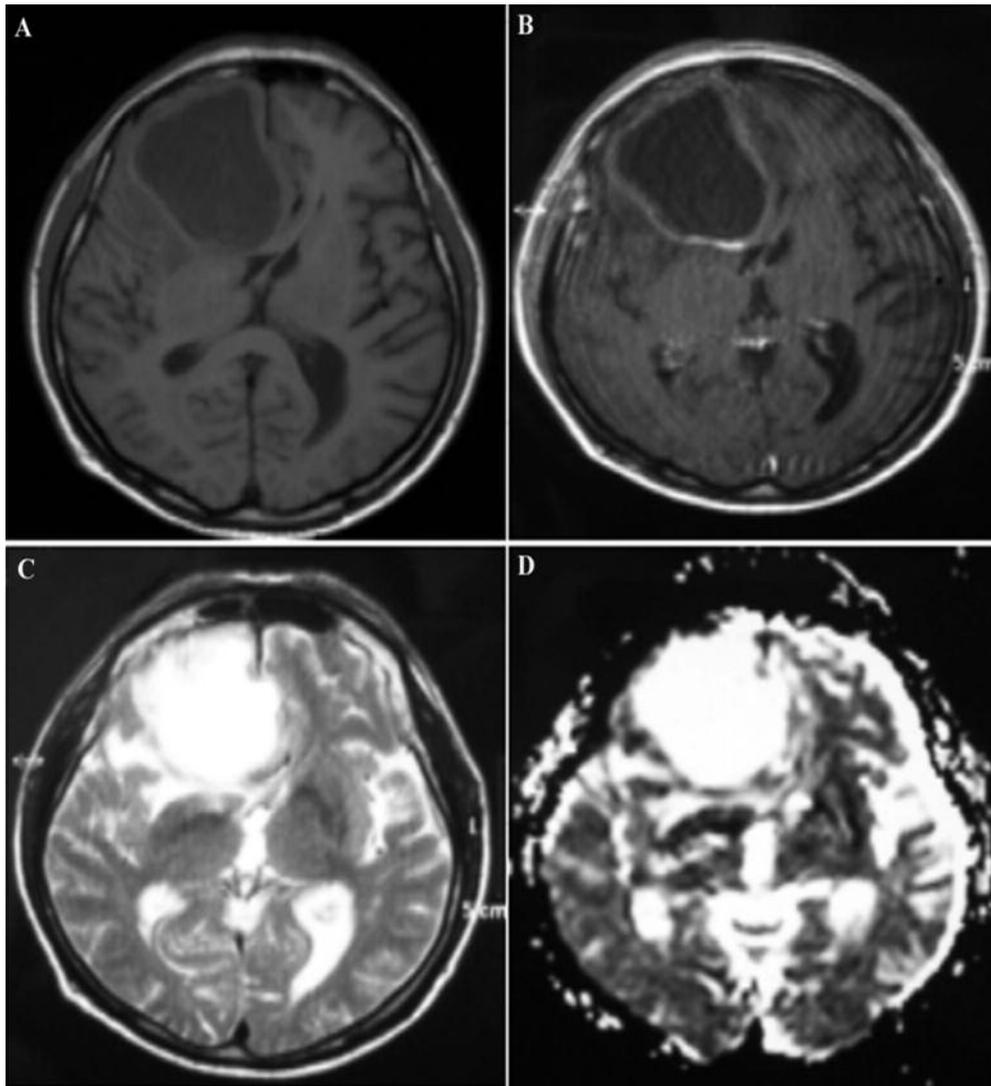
Brain MRI. A. Plain axial-T1 weighted scan shows a mass with low signal intensity surrounded by edema in the right frontal lobe. Midline shift is also observed. B. Contrast-enhanced axial-T1 weighted scan, shows rim enhancement. C. Axial T2-weighted scan. The mass appears with high signal intensity. D. Apparent diffusion coefficient (ADC) map, the lesion exhibits signal intensity similar to that of CSF, suggesting free diffusion.
